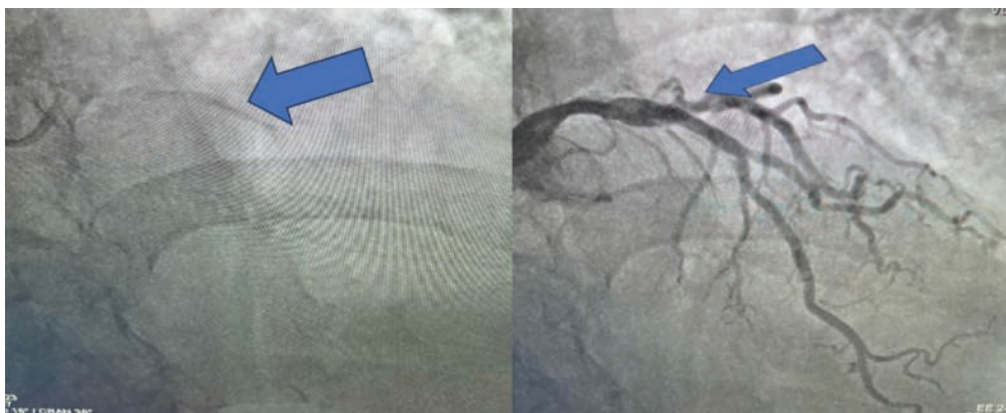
Patient had a positive calcium scoring test and radiographic evidence of CAC. Angiogram revealed coronary arteries with mild, non-obstructive disease.
